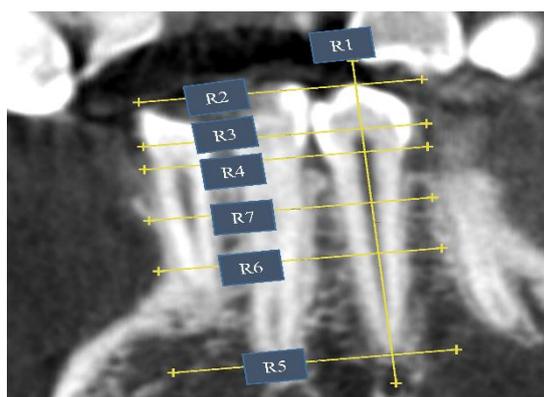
Reference lines drawn for standardization of linear measurements on CBCT sagittal sections in mandibular first premolar
